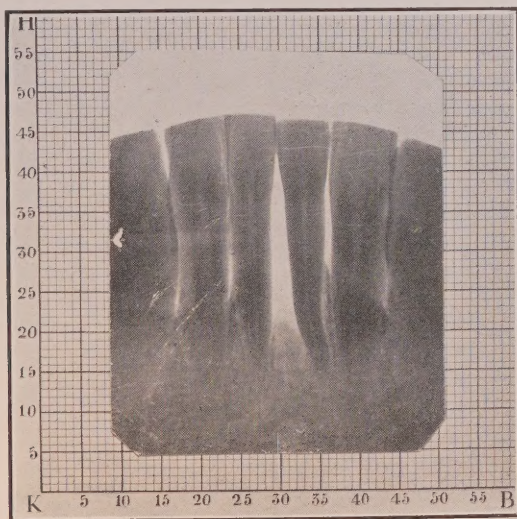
Regeneration of Alveolar Bone. Radiograph taken Mar. 1, 1921. Note that marked rarefaction of bone has occurred in the septal bone between lower central (median line). Age 43.
